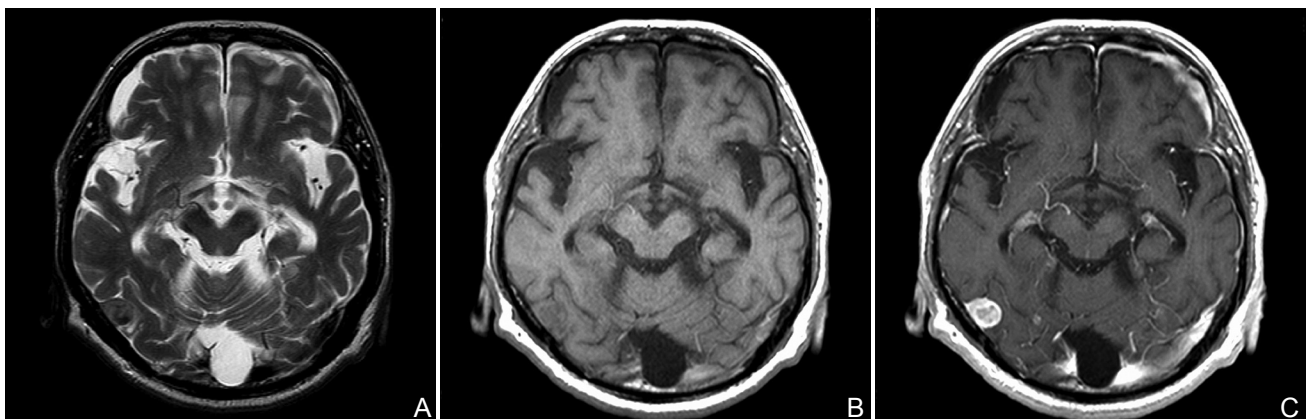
Magnetic resonance images in a patient with the convexity meningeioma. (A) Axial unenhanced T₂w image, (B) unenhanced T₁w image. (C) Gadobutrol-enhanced T₁w image shows strong enhancement of the tumor with clearer border delineation than unenhanced T₁w and T₂w images. Inhomogeneous enhancement reflects internal morphology of the tumor.
